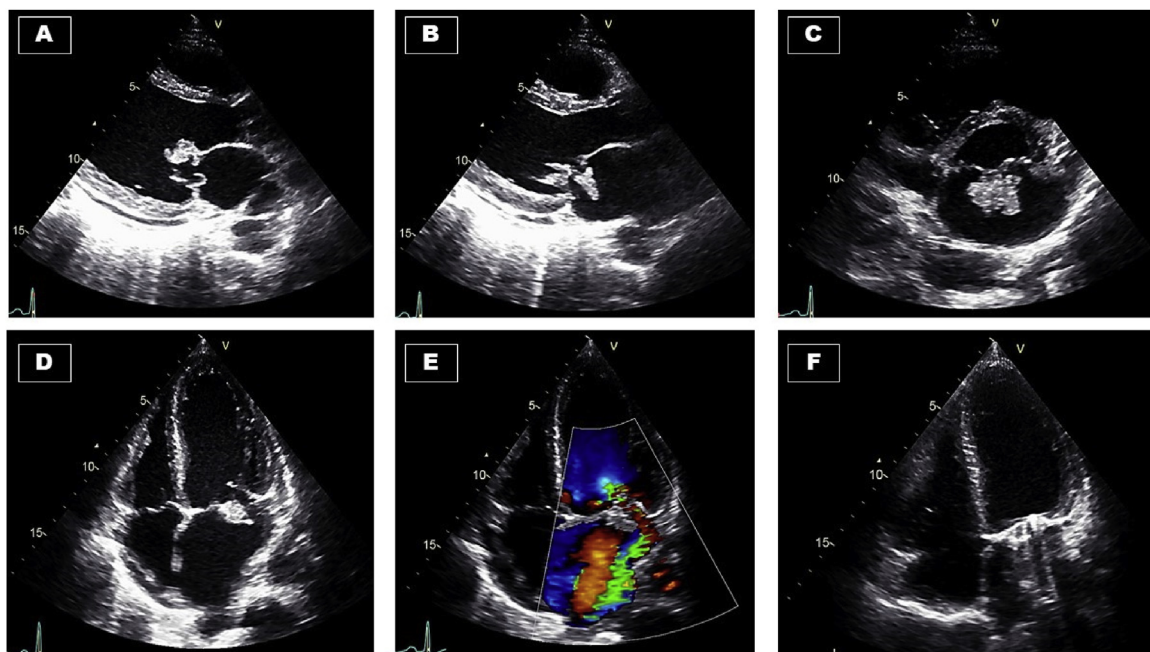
Transthoracic echocardiographic images: A: Parasternal long axis view. There is a large vegetation that measured 10x17 mm attached to the atrial surface of the anterior mitral valve leaflet. B: The vegetation and the flail anterior leaflet completely prolapse into the LA. C: Off-axis parasternal short axis view showing the large vegetation attached to the tip of the anterior mitral leaflet. In this view, the vegetation measured 19x24 mm. D: Apical four chamber view. The vegetation is attached to the tip of the anterior mitral valve leaflet. E: Severe mitral regurgitation. F: Postoperative apical four chamber view showing a bi-leaflet mechanical prosthesis in the mitral position.
